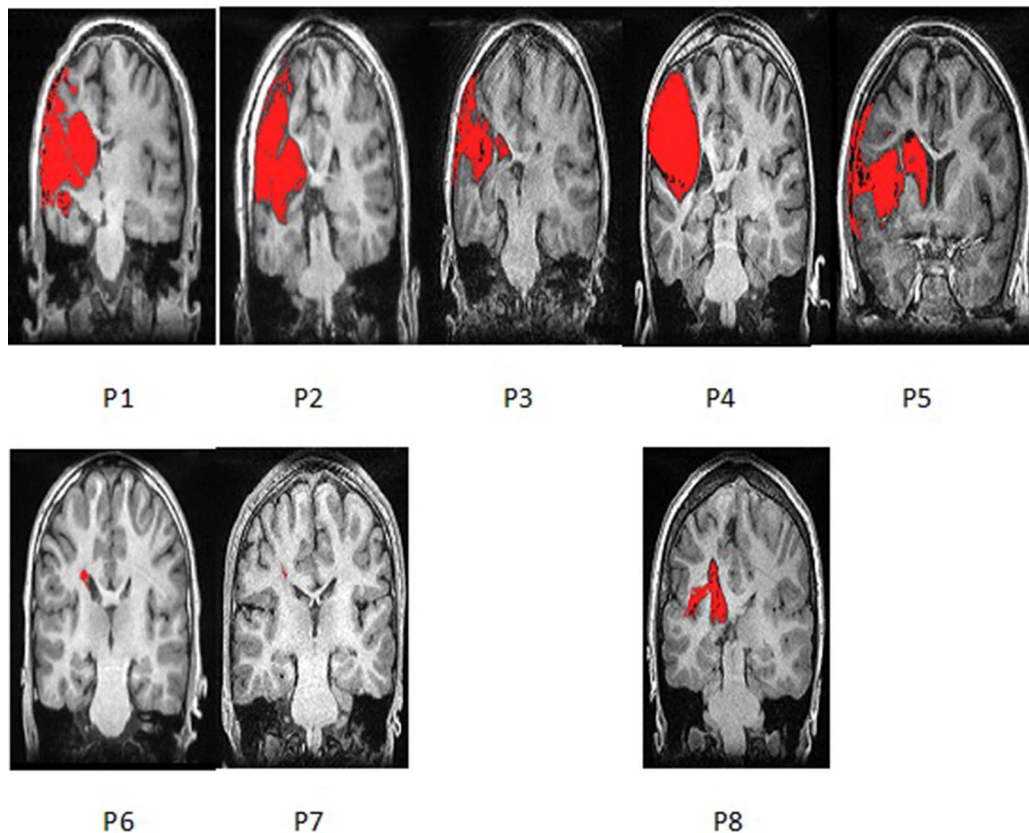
Coronal section of T1 Structural MRI of all eight patients showing their brain lesions (lesion represented in red color). Images are presented via MRICron and therefore flipped—left side of the brain is on the left side of the image.
